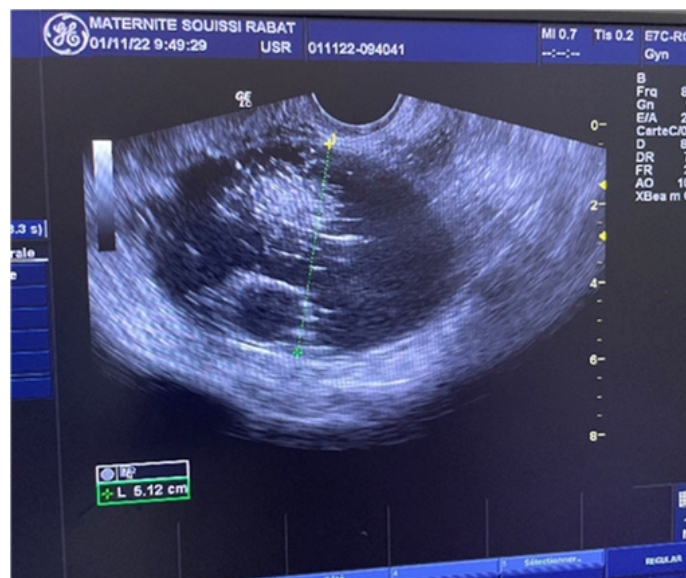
Ultrasound photography of the right ovarian mass compatible with ovarian mature cystic teratoma.
